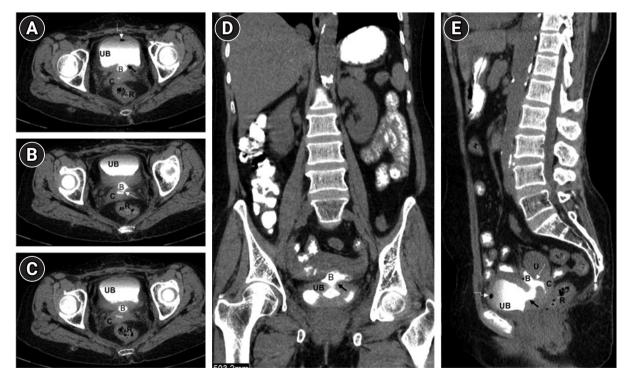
(A–E) Axial and reconstructed coronal and sagittal computed tomography images of abdomen and pelvis with oral contrast show enterovesical fistula (thick black arrow) between the ileal loop (B) and urinary bladder (UB), and enterocervical fistula (thin white arrow) between the ileal loop (B) and cervix (C). Oral contrast is seen in the bowel loops in the abdomen, bladder, cervix, and the ileal loop (B) interposed between the UB and uterus (U). Air focus seen in the bladder (white elbow arrows) is an indirect sign of vesical fistula. Normal rectum (R) is seen posteriorly in the images.
